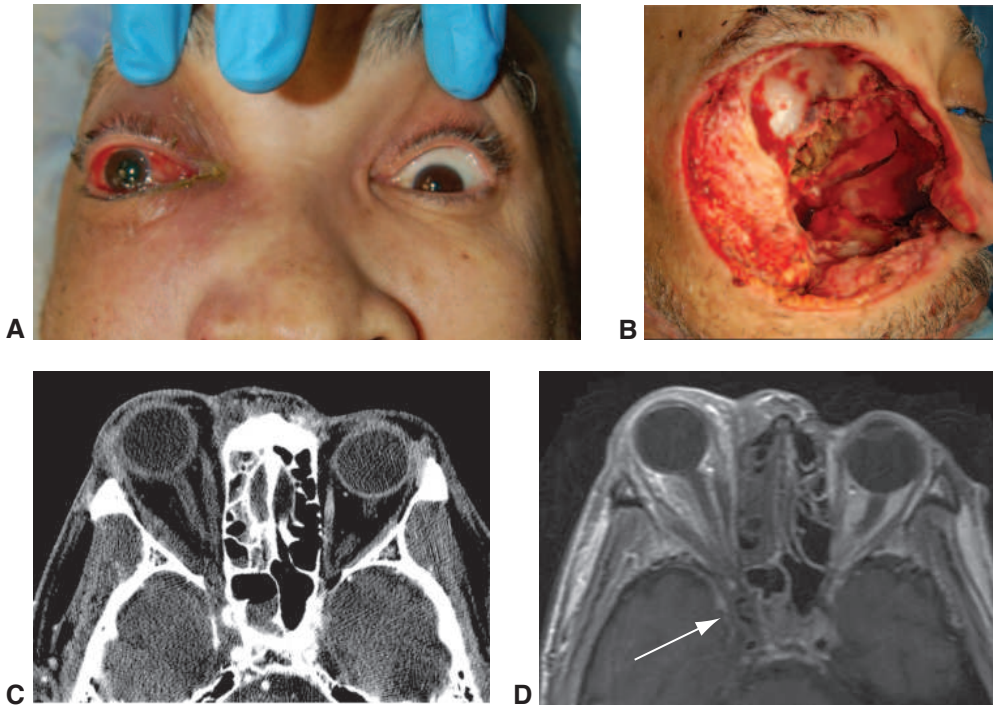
Right-sided sino-orbital invasive fungal sinusitis in a patient with diabetic ketoacidosis. A, Patient demonstrates complete right upper-eyelid ptosis and ophthalmoplegia. B, Wide surgical debridement consisting of orbital exenteration and sinus surgery was lifesaving. CT (C) and MRI (D) axial scans show orbital and sinus involvement as well as cavernous sinus thrombosis (arrow). (Courtesy of Bobby S. Korn, MD, PhD.)
